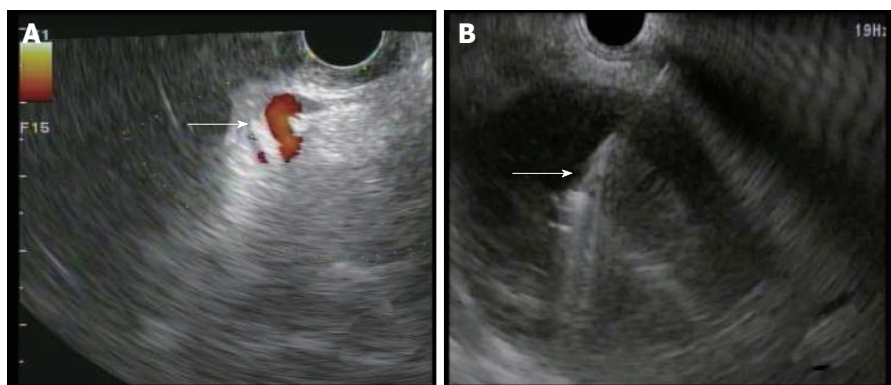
Endoscopic ultrasound of walled off necrosis. A: Doppler used to visualize any intervening vessels (arrow) including varices; B: FNA needle (arrow) seen entering necrotic cyst under EUS guidance. EUS: External urethral sphincter; FNA: Fine-needle aspiration.
